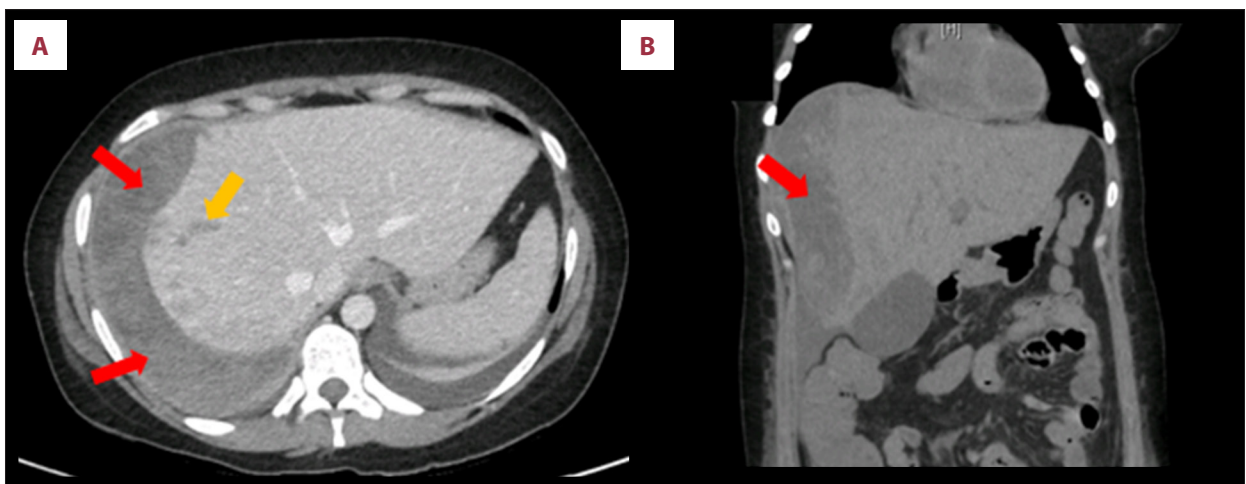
Abdomen-pelvis computed tomography scan without contrast. Axial plane (A); coronal plane (B). Acute-subacute hepatic subcapsular hematoma of 185CC \times 165AP \times 50T mm (red). Several liver injuries, the largest one 55 mm long (yellow). Moderate amount of fluid in the subhepatic, right parietocolic, and pelvic areas.
